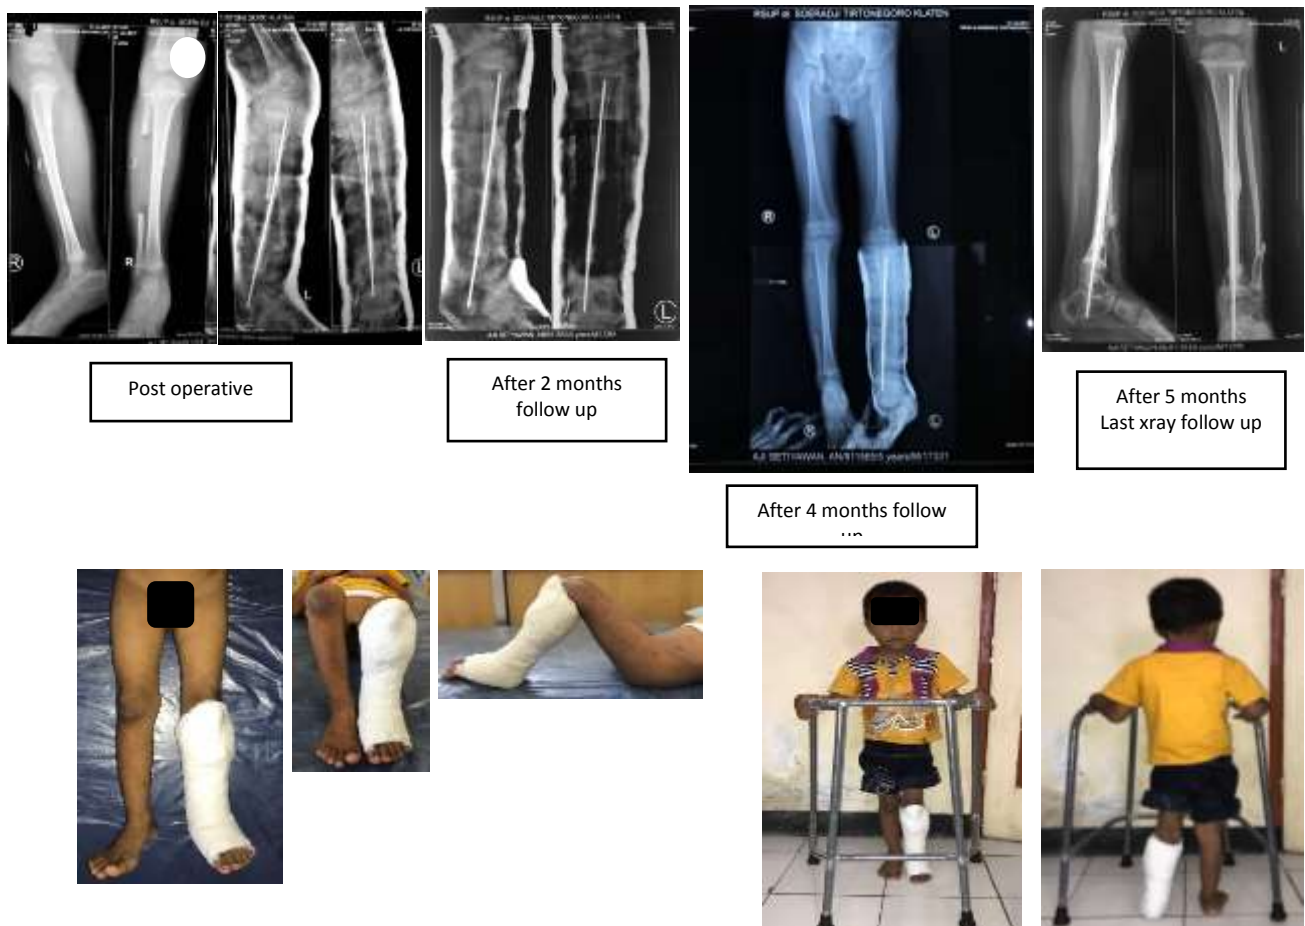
Post-operative xray resulted bony union, from clinically can standing and walk
